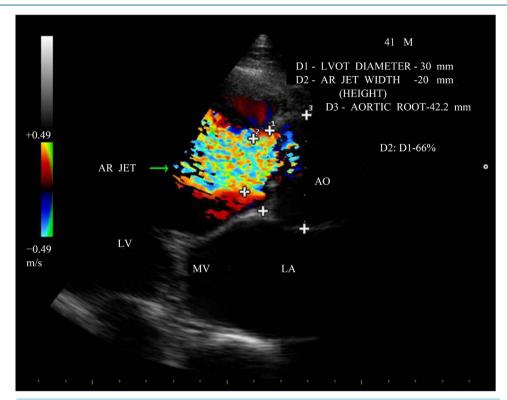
Parasternal long axis view showing the central AR jet in color-doppler imaging—JH/LOVH (Jet height/left ventricular outflow tract height) ratio—66%—severe AR.
